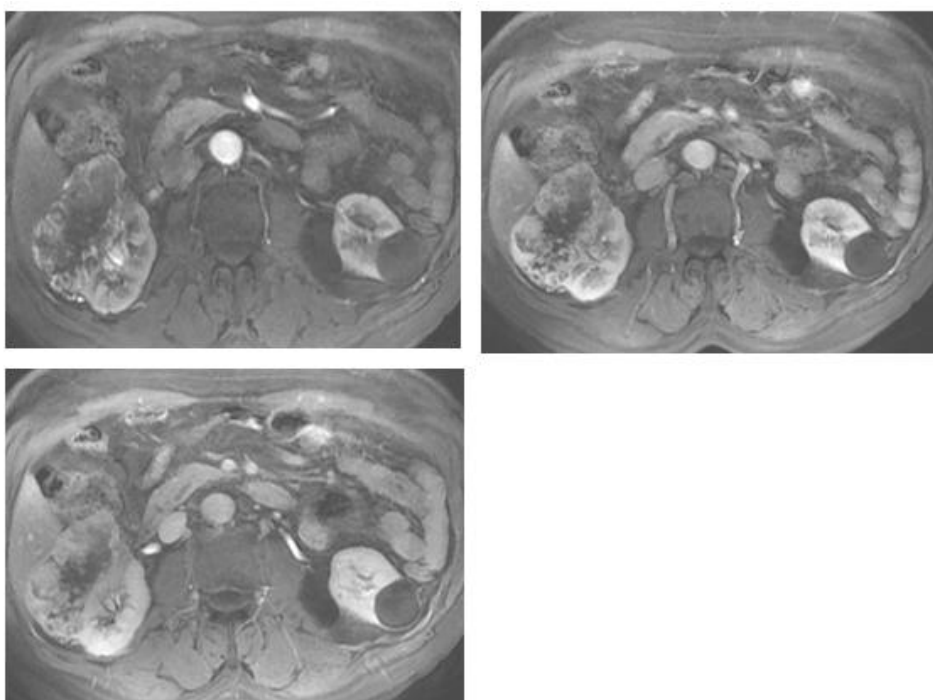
axial images of dynamic enhanced MRI showing right large heterogeneous enhanced renal solid mass at early phases and wash out at delayed phase .
